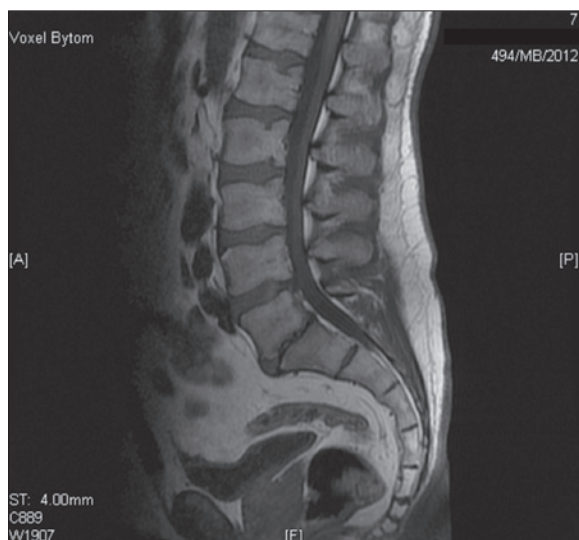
T1-weighted magnetic resonance scan obtained in a patient not diagnosed with myelodysplastic syndrome.
